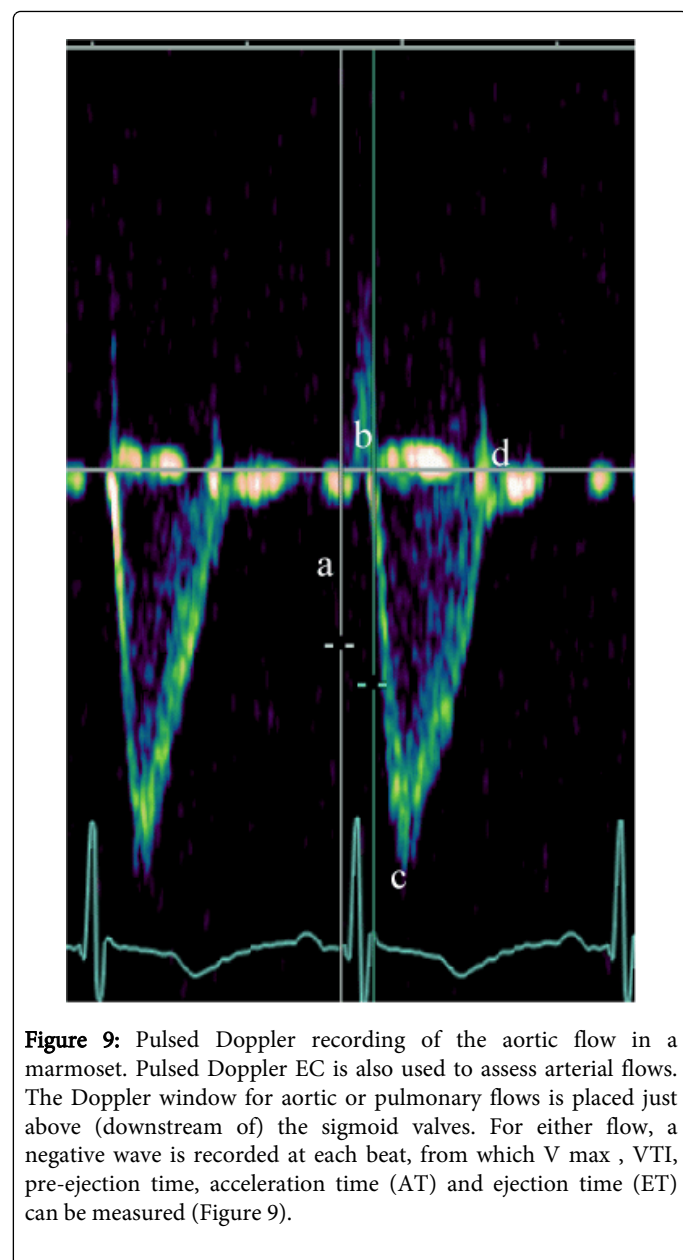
Pulsed Doppler recording of the aortic flow in a marmoset. Pulsed Doppler EC is also used to assess arterial flows. The Doppler window for aortic or pulmonary flows is placed just above (downstream of) the sigmoid valves. For either flow, a negative wave is recorded at each beat, from which V max , VTI, pre-ejection time, acceleration time (AT) and ejection time (ET) can be measured (Figure 9).
